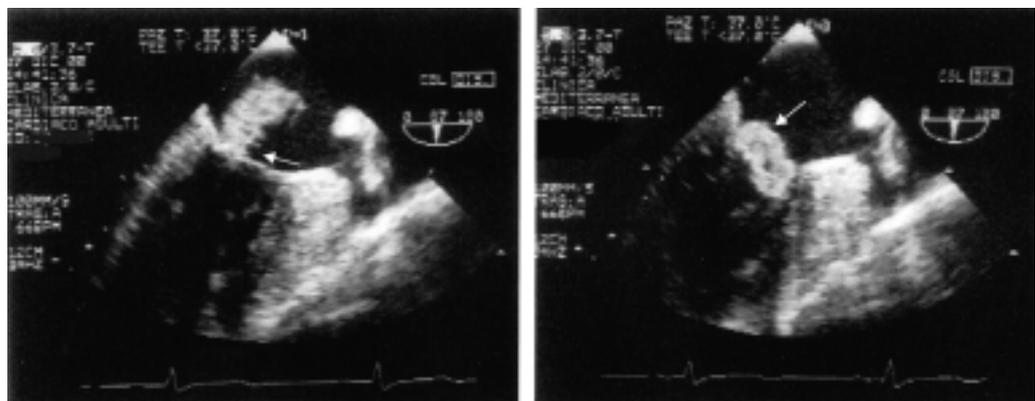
Transesophageal echocardiographic 2-chamber views showing a large vegetation attached to the posterior hemiannulus of the mitral valve during systole (left panel) and during diastole (right panel) when it occupies the atrioventricular orifice.
